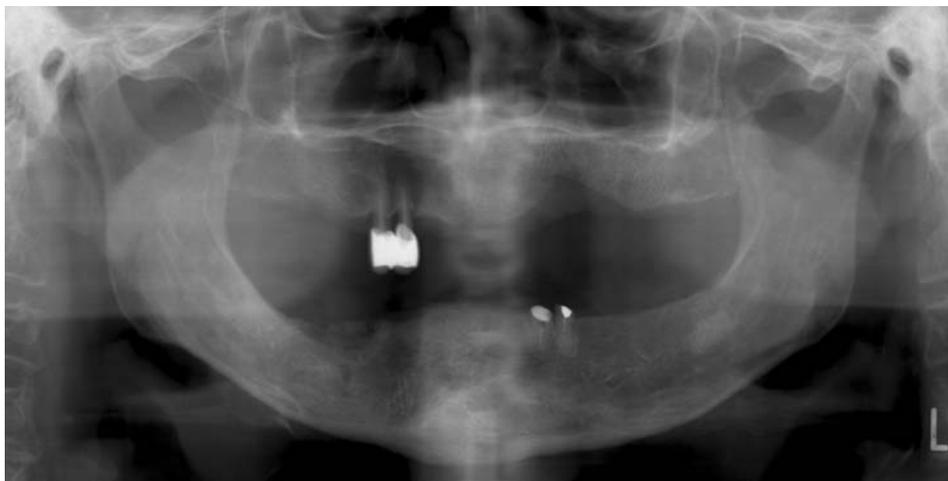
Panoramic radiograph shows decreased bone density and sequestrum on right mandibular area.
